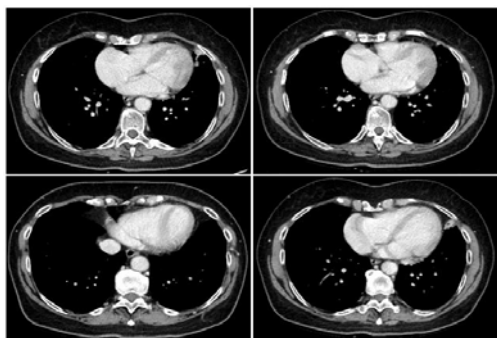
Chest CT with contrast medium performed in February 2014. Enhanced CT demonstrated multiple acinar opacities associated with thickening of the peripheral bronchi in both lungs subsequently interpreted as bronchoceles.
